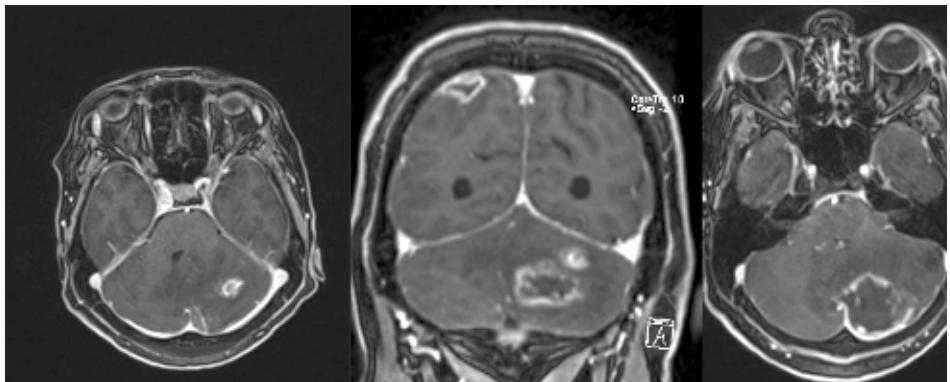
MRI on admission .
